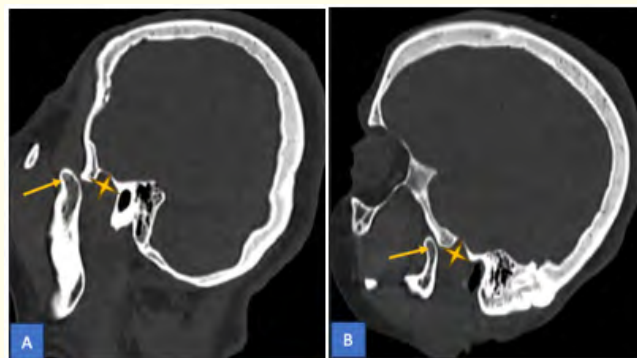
Sagittal (A, B) and coronal (C) CT scan of the facial massif with bone window showing the anterior displacement of the condyle (yellow arrow) relative to the mandibular fossa (yellow star) on the right and left side.
